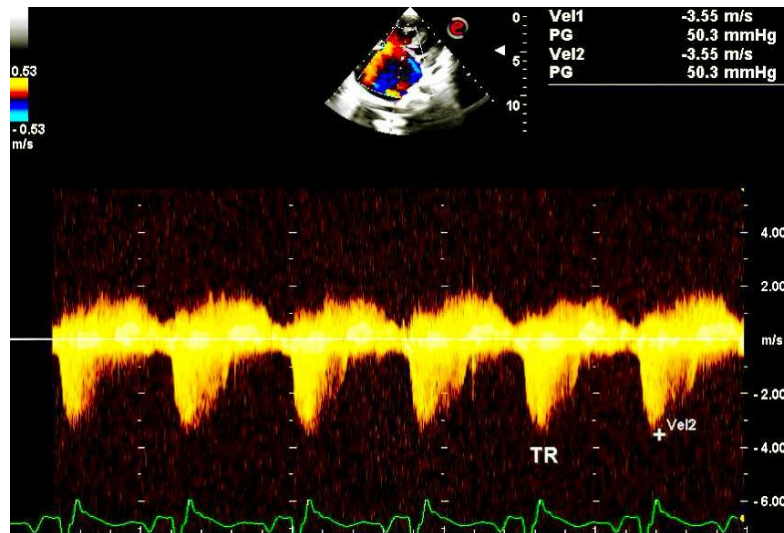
Severe pulmonary hypertension. On continuous wave doppler (CWD) analysis across the TV, a CWD signal of TR is depicted with a peak velocity of 3.55 m/sec and a peak gradient of 50 mmHg. The estimated right ventricular systolic pressure (RVSP)/pulmonary artery pressure (PAP) was 60 mmHg.
